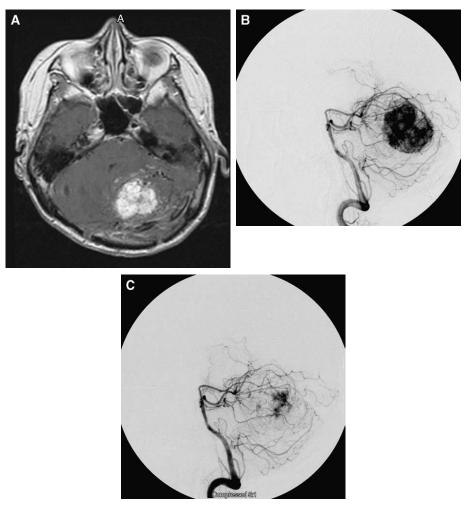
(A) Axial postcontrast MRI shows an intensely enhancing posterior fossa mass. (B) The vertebral artery injection shows the dense vascularity of a hemangioblastoma. (C) The deep arterial supply is obliterated with glue embolization.
